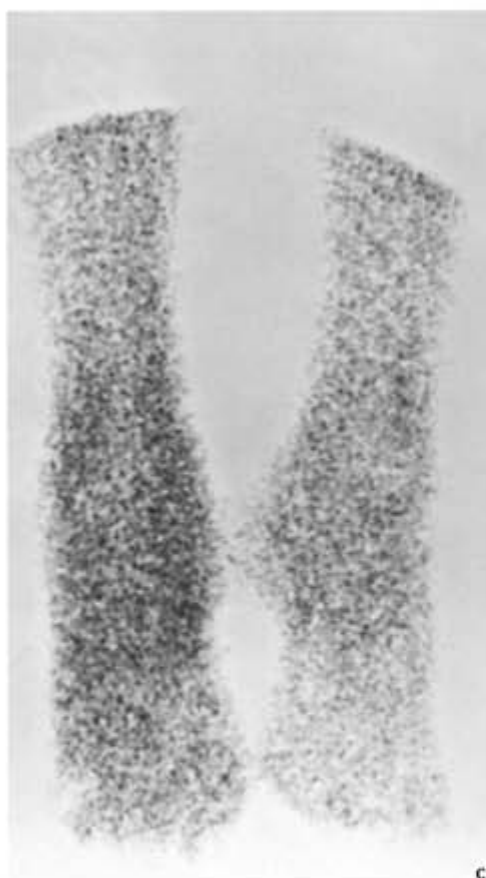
CT of bone abscess. A 7-year-old boy had intermittent pain in the left knee for 3 weeks; the pain was worse at night and was promptly relieved by salicylates. (A) Initial anteroposterior radiograph of the left knee demonstrates a radiolucent lesion with a well-defined, partly sclerotic border in the lateral portion of the distal femoral epiphysis. Osteoid osteoma and chondroblastoma were considered in the differential diagnosis. (B) CT examination, however, reveals cortical disruption at the posterolateral aspect of the lateral femoral condyle, a finding not seen on the standard radiographs. The serpentine configuration of the radiolucent tract and its extension into the cartilage prompted a diagnosis of epiphyseal bone abscess, which was confirmed on bone biopsy.
